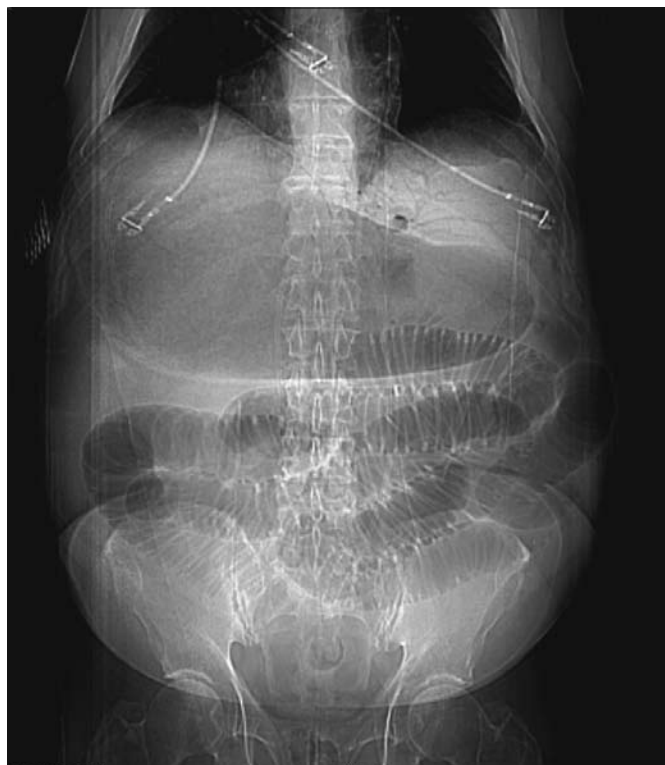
CT scout image showing massive gastric dilation.
